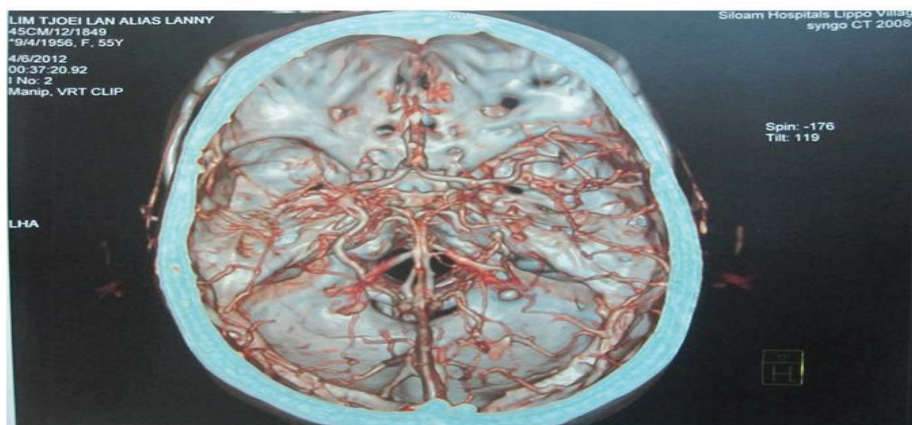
Preoperative CT Angiography Showing an Aneurysm at the Distal Anterior Choroidal Artery
